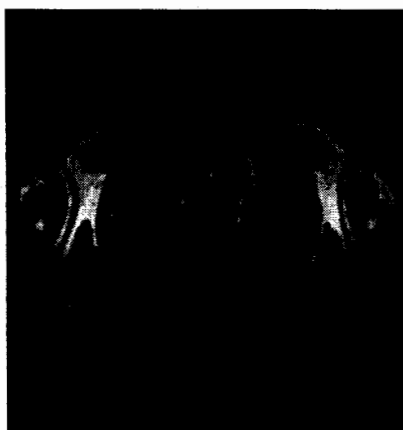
Registered MR image of Chest by Image Registration described by Huang et.al
